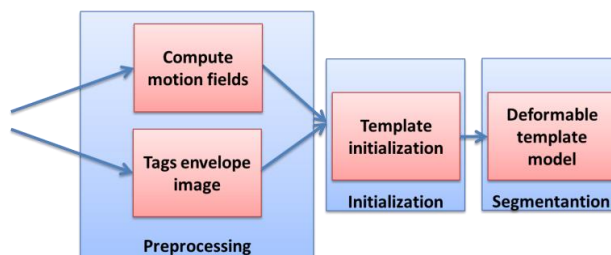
Block scheme for segmentation in t-MRI using the strategy proposed in [78].
